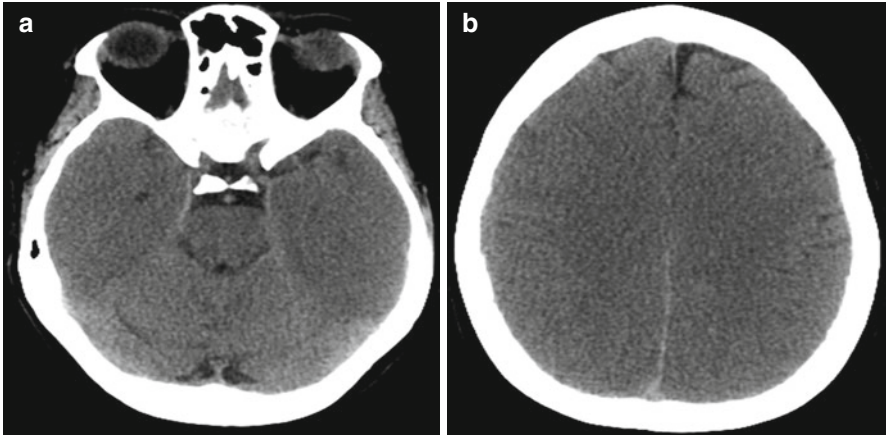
(a, b) Non-contrast enhanced head computed tomography (CT) in a patient 24 h after a motor vehicle collision shows diffuse loss of gray/white matter interface with sulcal and basilar cistern effacement consistent with diffuse cerebral edema. Note that the cerebellum is spared and appears brighter than the cerebral hemispheres
